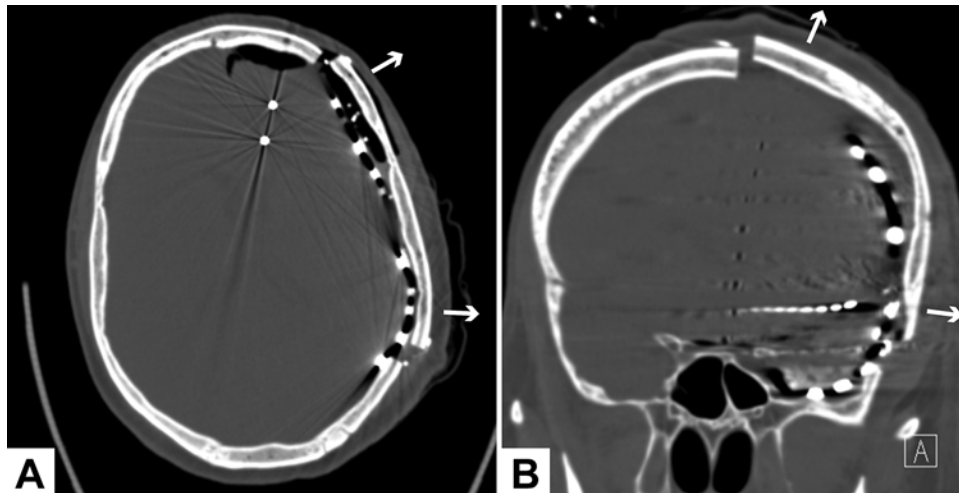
Postoperative CT images showing the elevated bone flap. A: Axial CT image in bone window showing the bone flap in the elevated (white arrows) position. B: Coronal CT image in bone window showing the elevated bone flap (white arrows).
